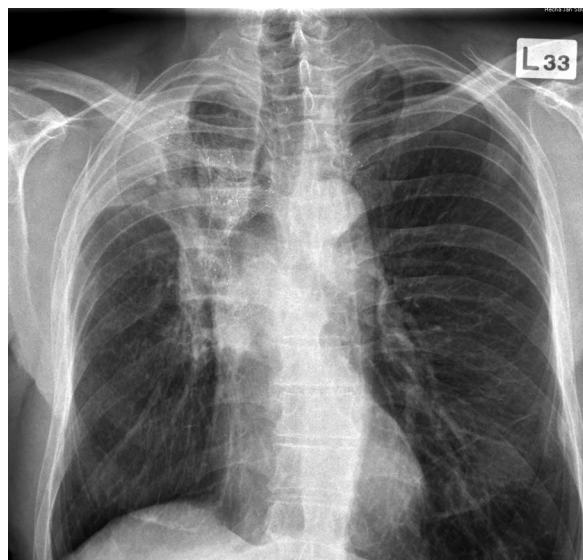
Tumor at the apex of the right lung (chest X-ray)
